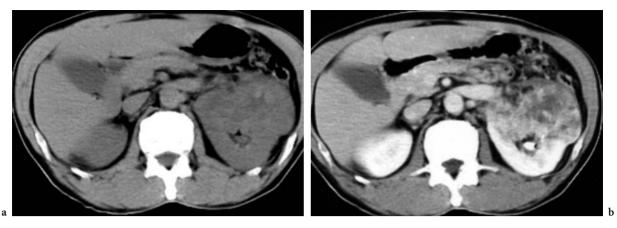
Collecting duct carcinoma in a 65-year-old man. a Axial unenhanced CT scan shows an ill-defined, inhomogeneous hypodense mass in the left kidney. b Axial contrast-enhanced CT scan shows a heterogeneous enhancing mass with protrusion into the left renal pelvis.
